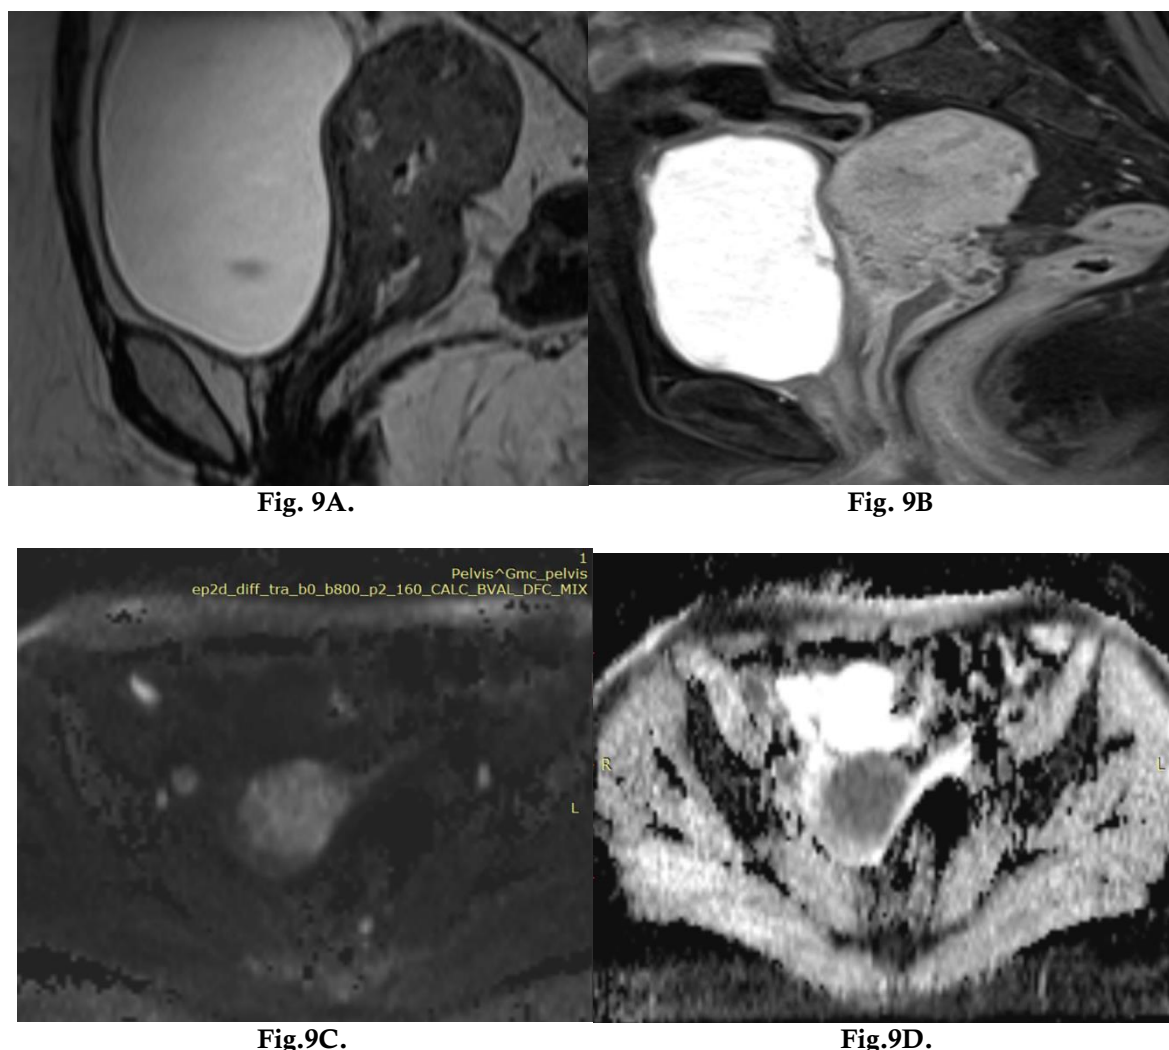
Sagittal T2WI (9A) shows an ill-defined hyperintense area in the cervical canal extending into body of uterus showing heterogenous enhancement on post contrast scan (9B). The mass depicts restricted diffusion on DWI (9C) & ADC (9D) - Biopsy was positive for Squamous cell carcinoma Cervix
